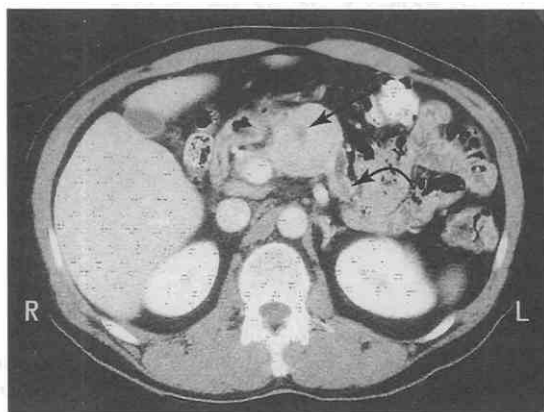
Acinar cell carcinoma. CT scan shows a well defined mass with a small area of necrosis. A dilated pancreatic duct is noted distally. (From Mustert B, et al: Appearance of acinar cell carcinoma of the pancreas on dual-phase CT. AJR Am J Roentgenol 171:709, 1998.)
